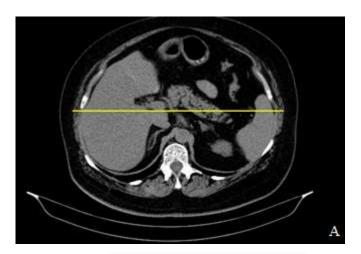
Measurement of the transverse diameter (DT) at the level of the T12 vertebra (A) and the diaphragm-infrasymphysial diameter (DDI) between the diaphragmatic dome and the inferior pole of the pubic symphysis (B) – CT aspect of the same patient.
